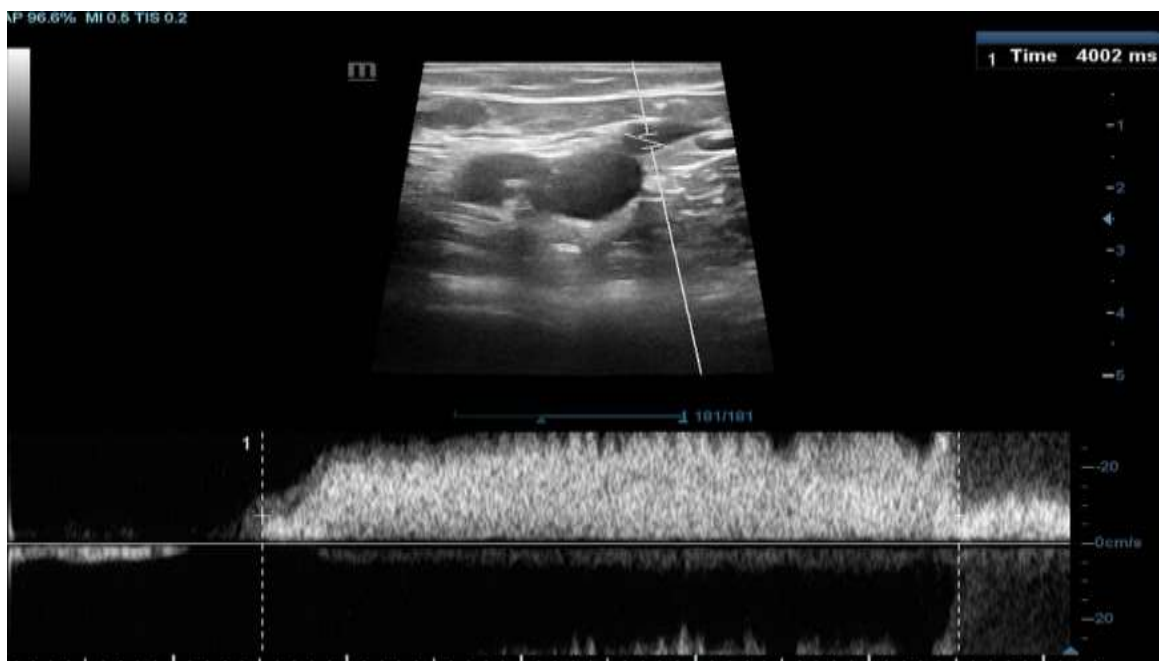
2. Spectral venous Doppler image at the level of sapheno-femoral junction demonstrating prolonged retrograde venous flow (venous reflux) with a reflux duration of 4002ms (4.002 s) which is suggestive of incompetent sapheno-femoral junction.
